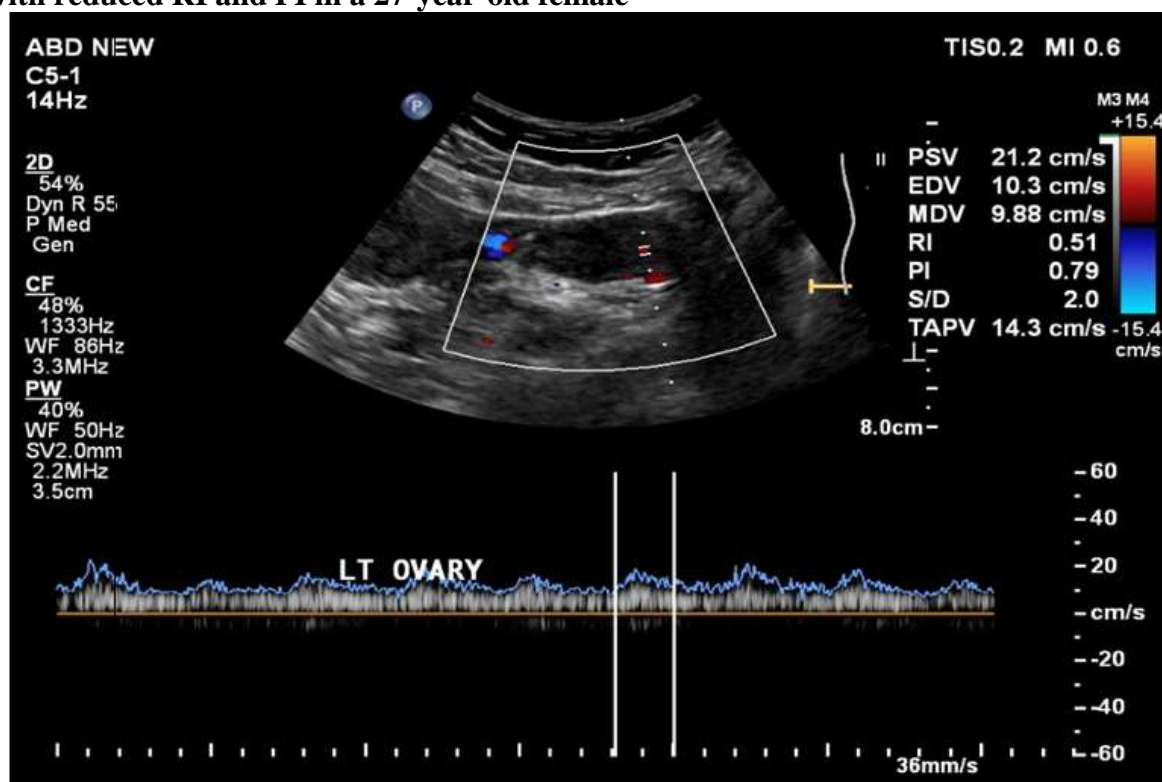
Spectral Doppler image showing abnormal wave pattern in polycystic ovary with reduced RI and PI
